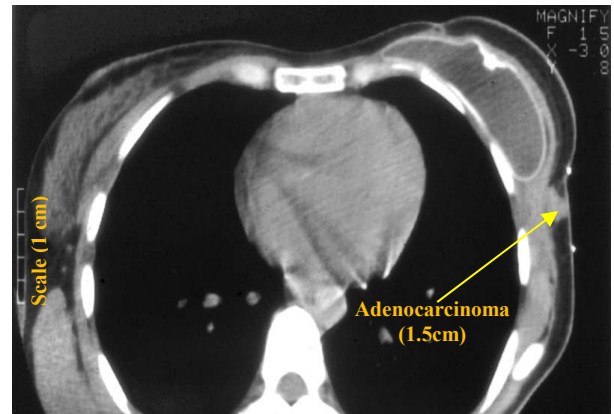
Transverse CT image of a female patient with CWR of breast cancer.
